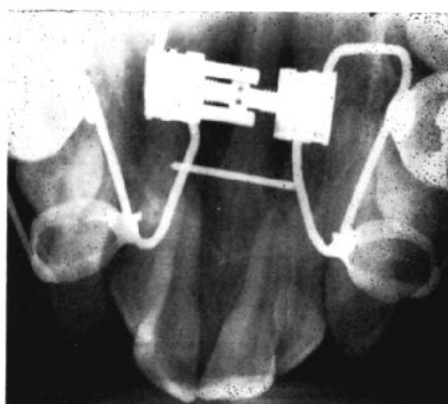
Radiographs made after reformation of the suture.
